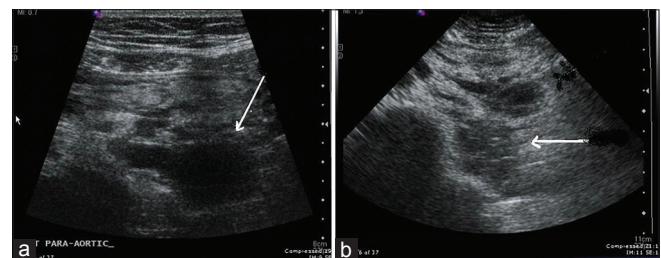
(a) Ultrasound revealing evidence of hypoechoic para-aortic masses (b) Ultrasound repeated after 1 week revealed resolution with decrease in size of the para-aortic hypoechoic masses
